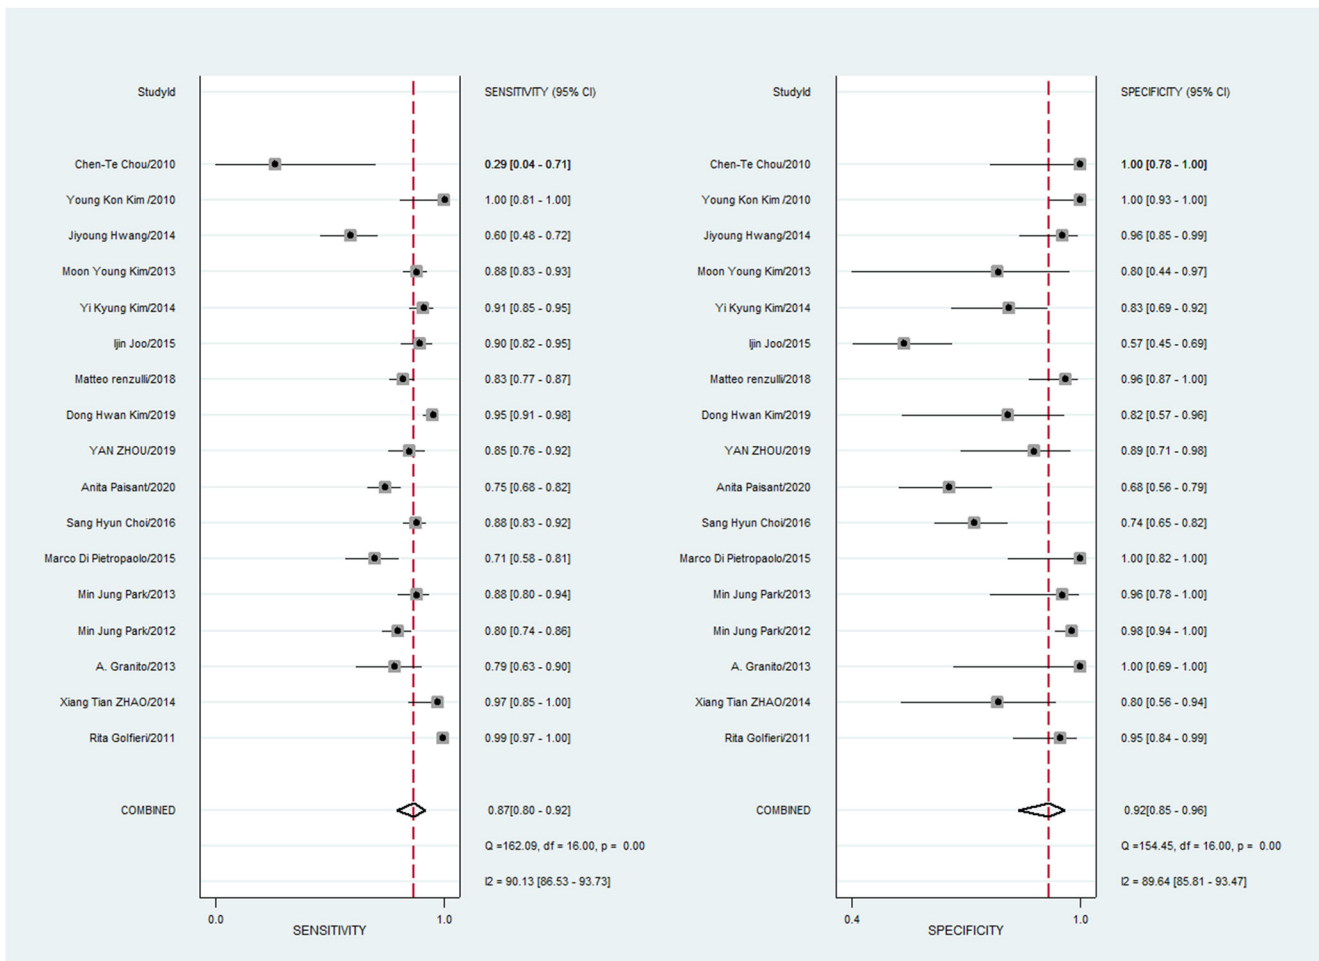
Summary estimates for the detection of HCC by using Gd-EOB-DTPA-enhanced MRI with HBP
